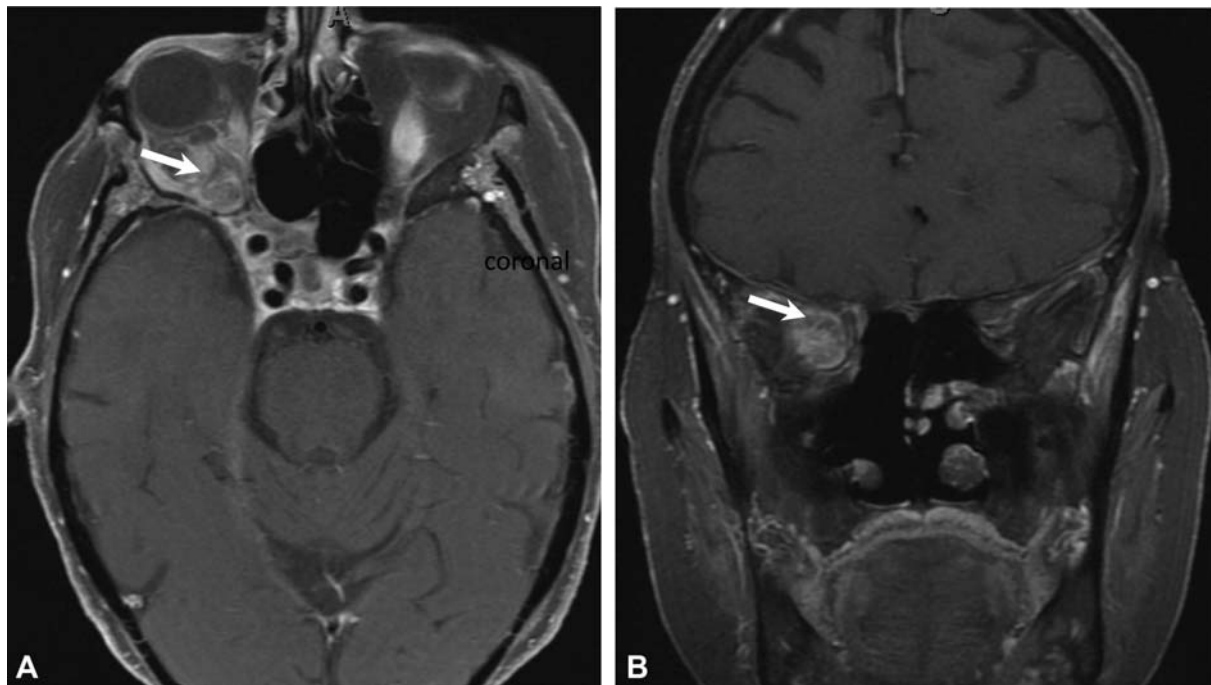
Preoperative axial (A) and coronal (B) post contrast T1-weighted MRI images showing a recurrent squamous cell carcinoma involving the superomedial orbit (arrow) and extending to the orbital apex. MRI, magnetic resonance imaging.
